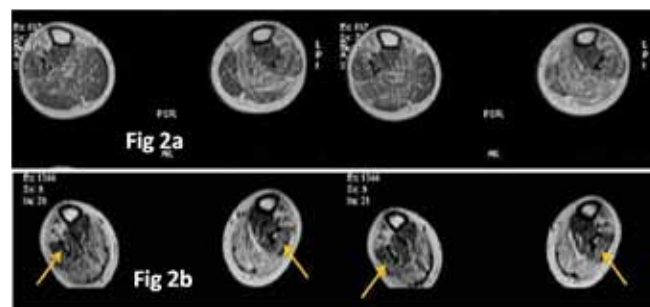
T1 Weighted axial MRI Images of Peroneus Longus and Brevis, before BMMNCs transplantation
